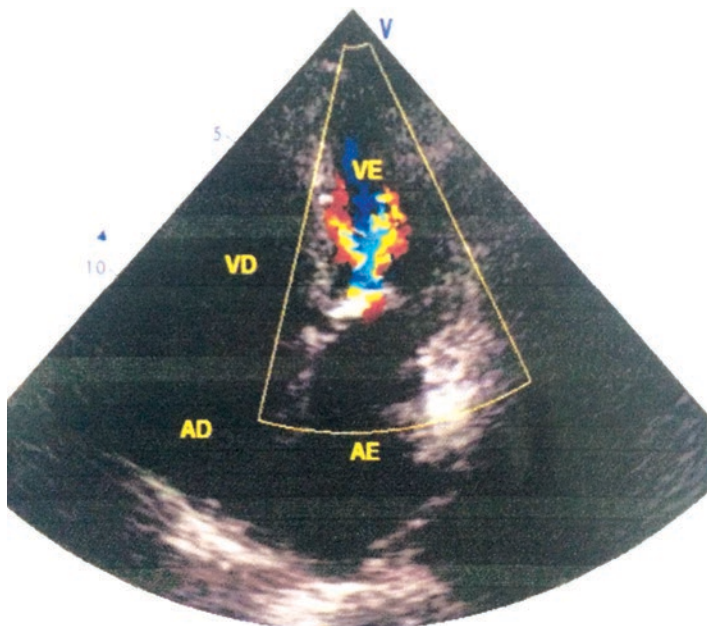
Echocardiography photo of the four cardiac chambers showing turbulent flow at the left ventricle due to severe mitral stenosis
